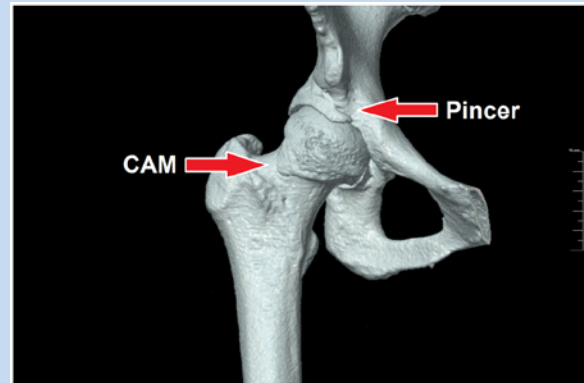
Three-dimensional computed tomography scan demonstrating combined cam and pincer deformities.
